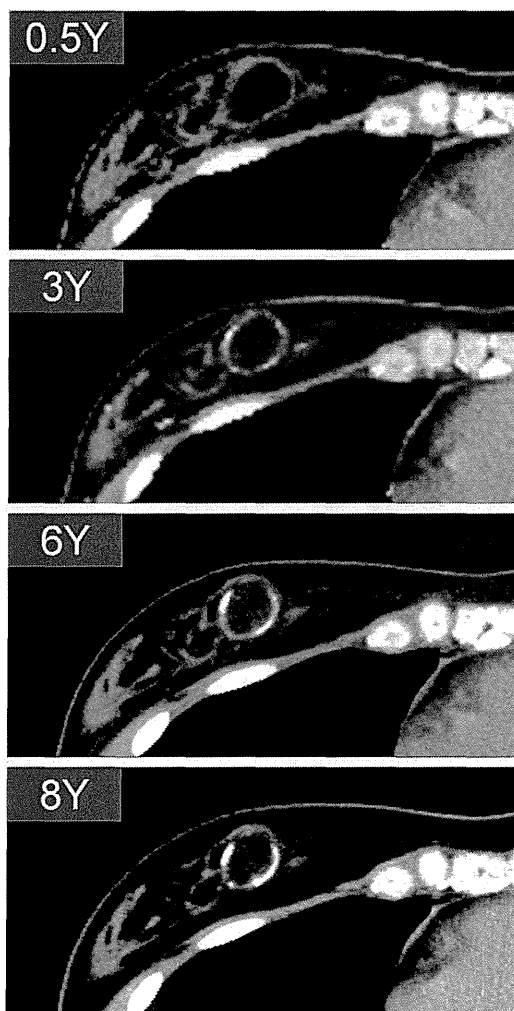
Sequential computed tomographic images of oil cysts taken from a patient (34-year-old woman) with multiple oil cysts in both breasts who did not undergo any removal of the cysts. The size of the oil cysts did not change between 3 and 8 years, but calcification progressed during that period. (See also Figure, Supplemental Digital Content 5, <http://links.lww.com/PRS/A968>.)
